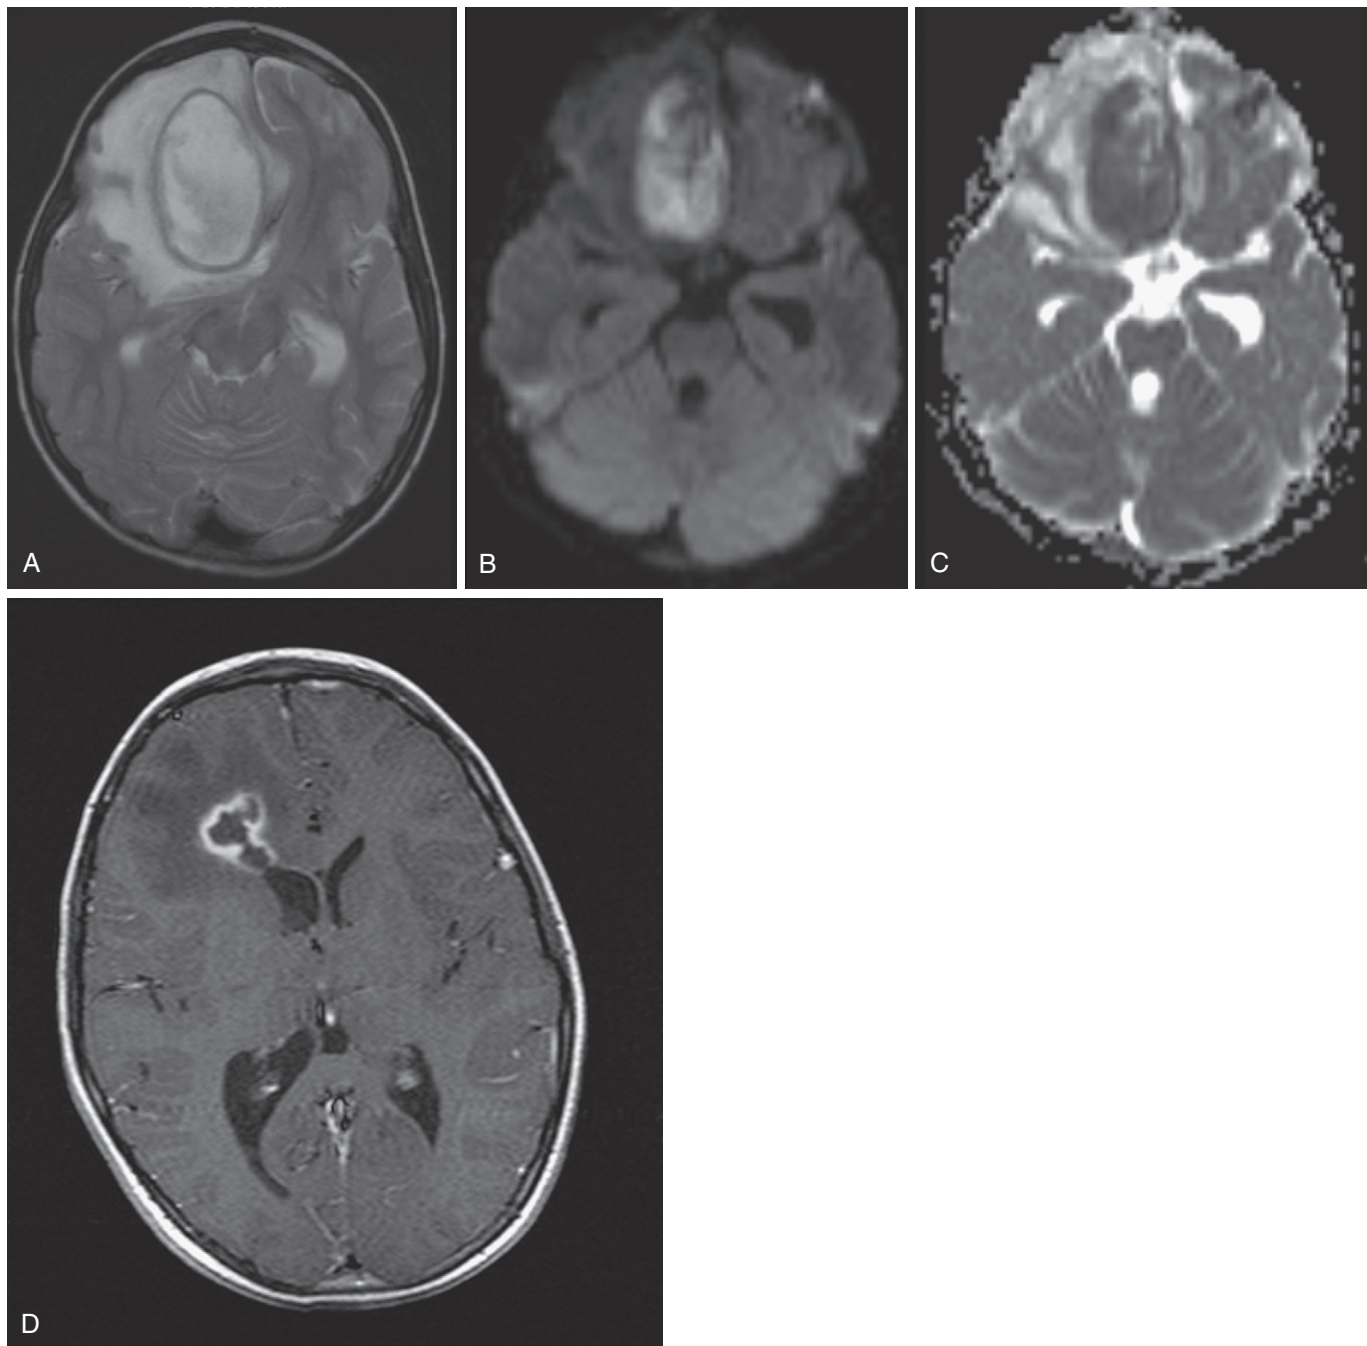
Frontal brain abscesses. Axial T2-weighted MRI (A) demonstrates a right frontal ring-enhancing lesion with a T2 hypointense capsule that has considerable surrounding vasogenic edema and leftward midline shift. The lesion is bright on diffusion (B) and dark on the apparent diffusion coefficient map (C), suggesting that it is diffusion restricted. D, In another patient, axial postcontrast T1-weighted MR image demonstrates a right frontal periventricular ring-enhancing lesion with T1 hypointense vasogenic edema surrounding it.
